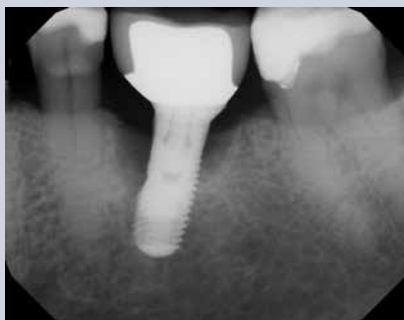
Radiograph after implantoplasty procedure. The threads on the distal of the implant are engaged in sound lingual bone and not removed.
